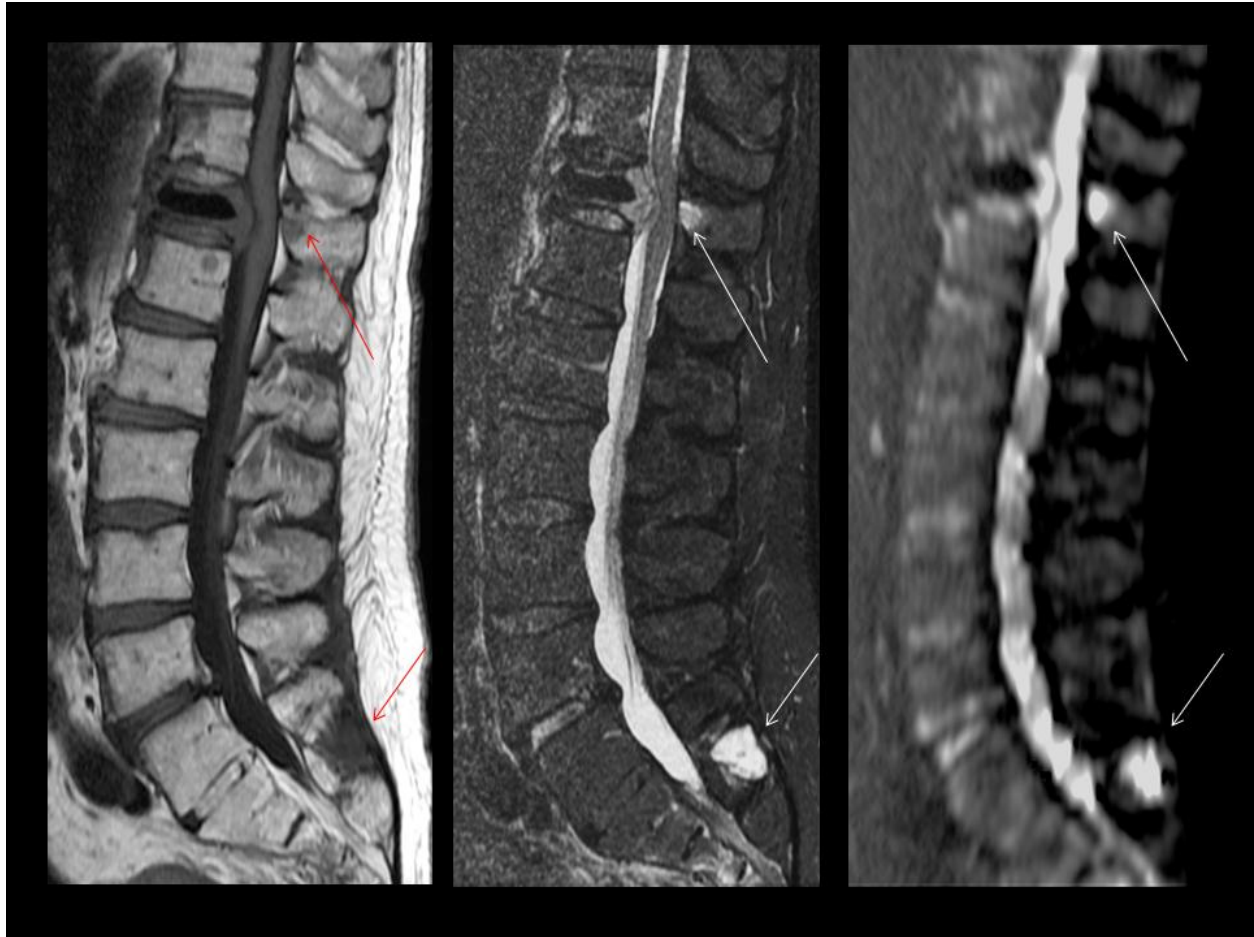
Metastatic myeloma. From left: T1 FLAIR, STIR, DWI. Note the striking conspicuity of the tumor (arrows) within the compressed, T11 vertebral body, post-vertebroplasty. Note also the posterior element tumor at L5.
